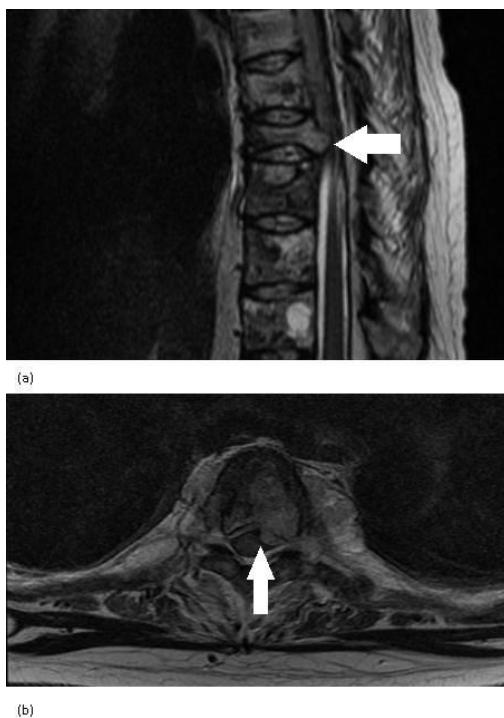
MRI Thoracic Spine (a) T2 weighted sagittal view confirming cord compression at D10-D11(b) T2 weighted axial view- also showing vertebral disease with cord compression.
